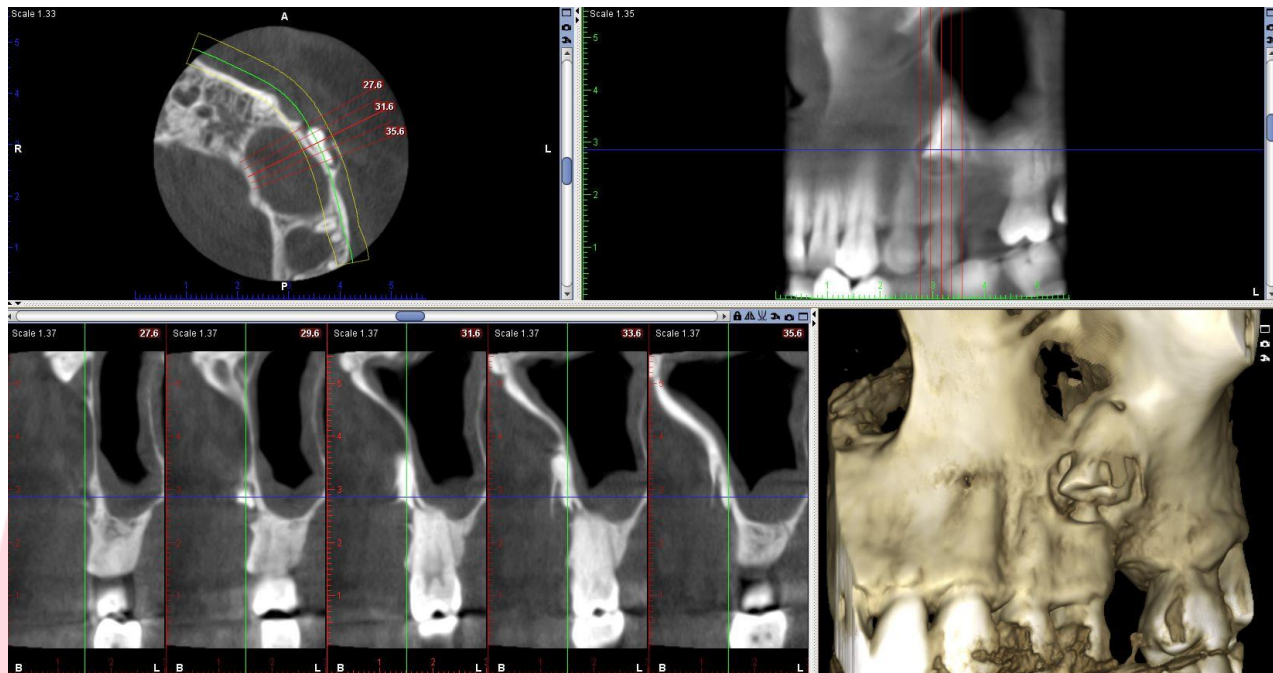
Preoperative cone-beam tomography view of the displaced dental root
